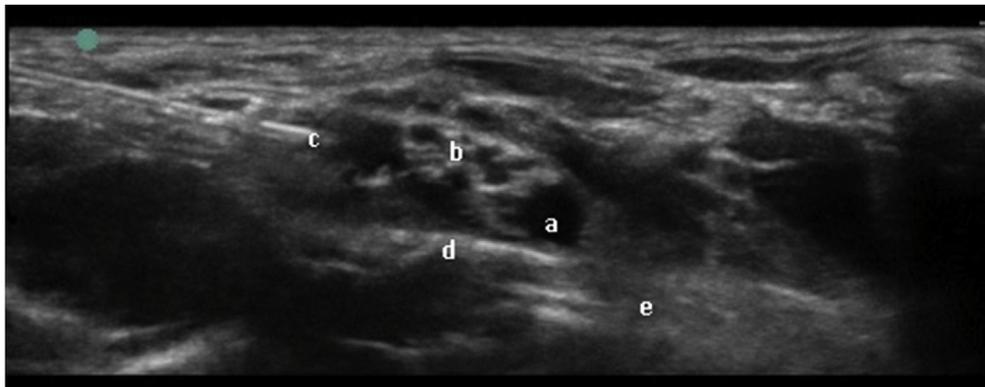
Ultrasound-guided supraclavicular nerve block (depth 1.8 cm). (a) Subclavian artery; (b) brachial plexus; (c) needle tip approaching brachial plexus; (d) rib; (e) pleura.
